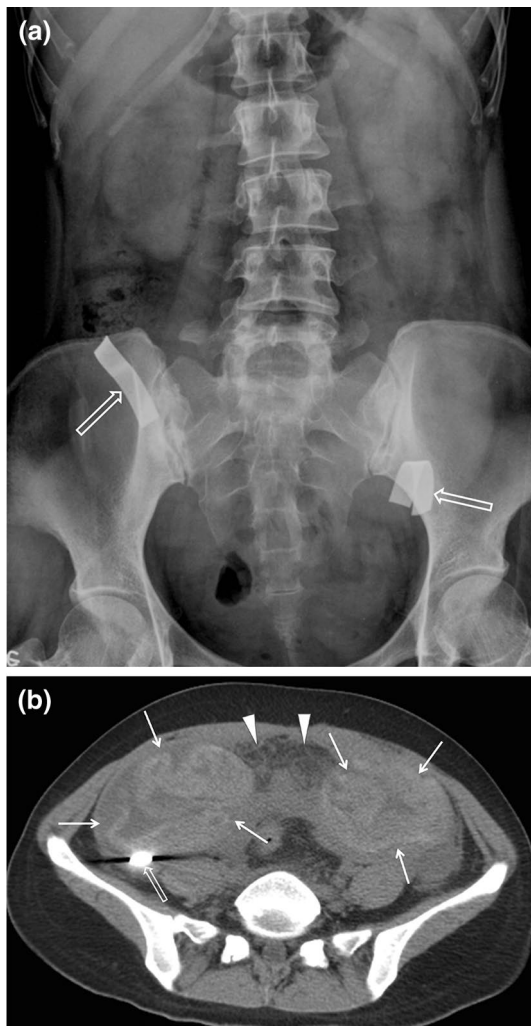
Retained surgical sponges with peritonitis in a 31-year-old female with history of a cesarean section 1 year earlier. a Abdominal radiograph shows two radiopaque sponge markers in the bilateral lower abdomen (*open arrows*). b Axial CT scan shows two ovoid-shaped masses (*arrows*) with inner subtle high density “whorled” configuration and greater omental infiltration (*arrowheads*) suggesting peritonitis. Note the beam-hardening artifact around the marker (*open arrow*). Sponges were surgically removed
